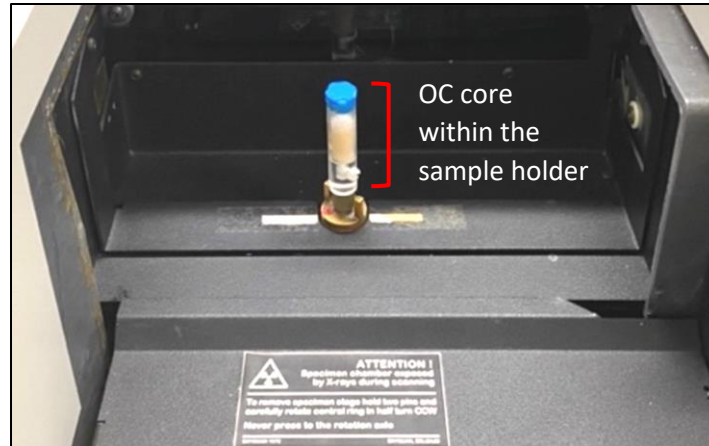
Custom-made polymethyl methacrylate sample holder hosting OC cores during μ CT acquisitions, performed to compute the AC thickness.
